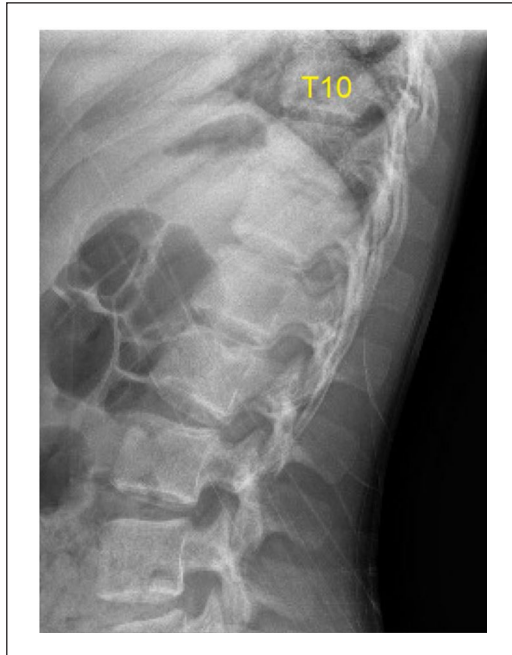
Spinal X-ray shows endplate irregularity is present at the inferior aspect of T11 and superior aspect of T12 with mild compression deformity of the anterior aspect of T11.
